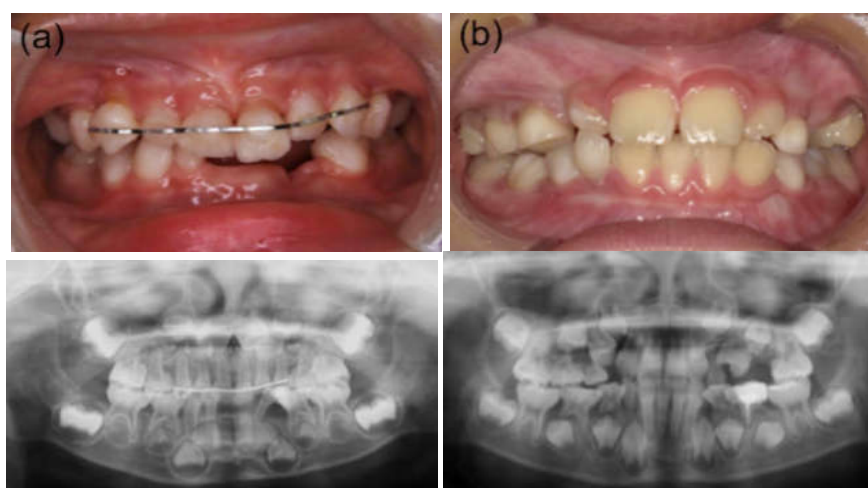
Photograph and X-ray of Case # 5: This is a 9 year old boy with HPP (36). A: Oral photograph taken at the age of 3 years and 11 months showing the absence of mandibular incisors and compression for the maxillary incisors. B: Oral photograph taken at the age of 9 years and 5 months showing the normal eruption of the 8 incisors without signs of inflammation. C: Panoramic X-ray taken at the age of 3 years and 11 months showing a reduced bone level around the lacteal teeth. D: Panoramic X-ray taken at the age of 9 years and 5 months showing the increase of the bone level around the permanent teeth.
